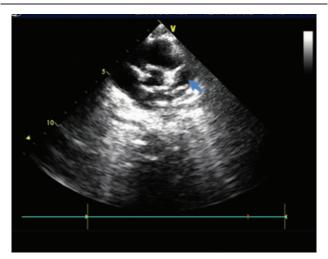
The echocardiographic image showing the aneurysm in the left coronary artery (the arrow).
